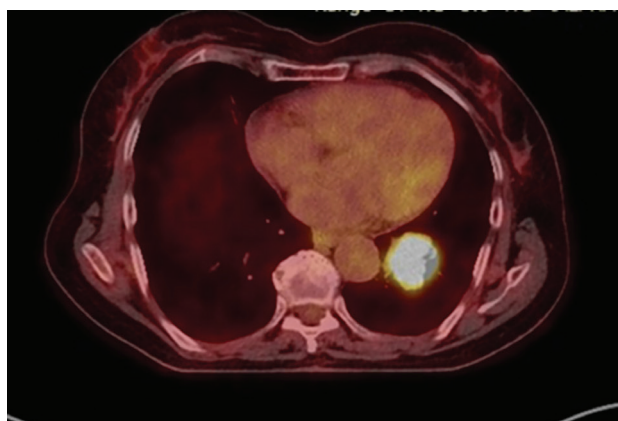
^{18}F FDG PET-CT showing avidity of the primary tumor in the left lower lobe (standard uptake value 24.1).
